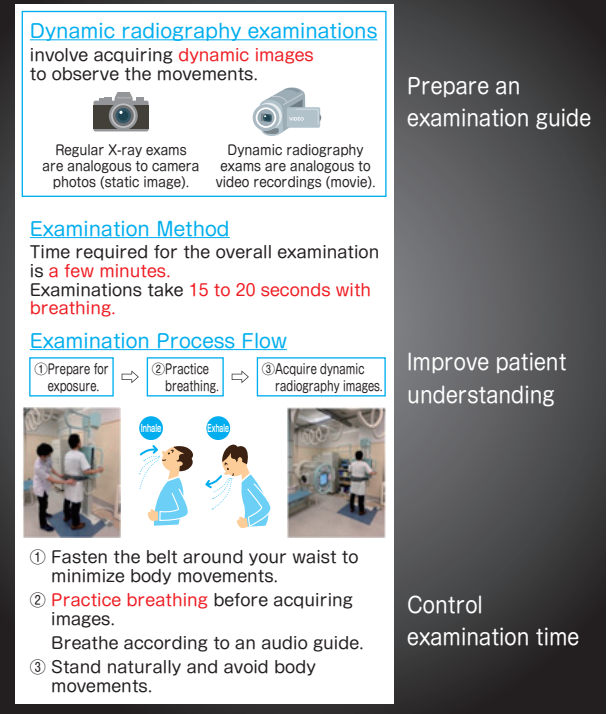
Dynamic Radiography Examination Guide
